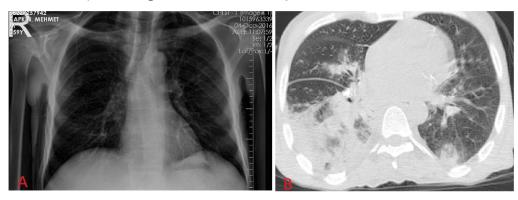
Normal chest X-ray imaging one week before infection and HRCT imaging bilateral pneumonic infiltration involved especially right lobe.
